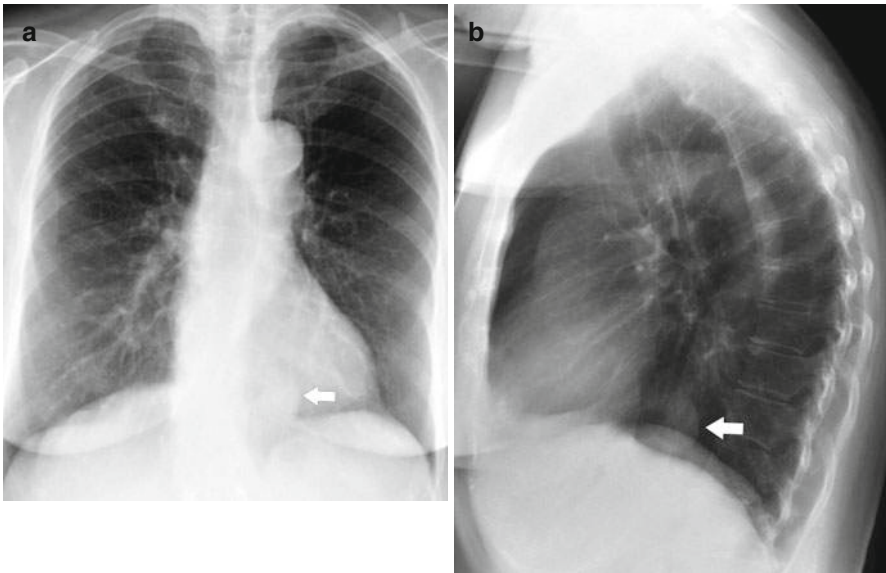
Hiatal hernia. Chest X-ray posteroanterior (a) and lateral (b) views show a soft tissue density (arrows) superior to the esophageal hiatus
